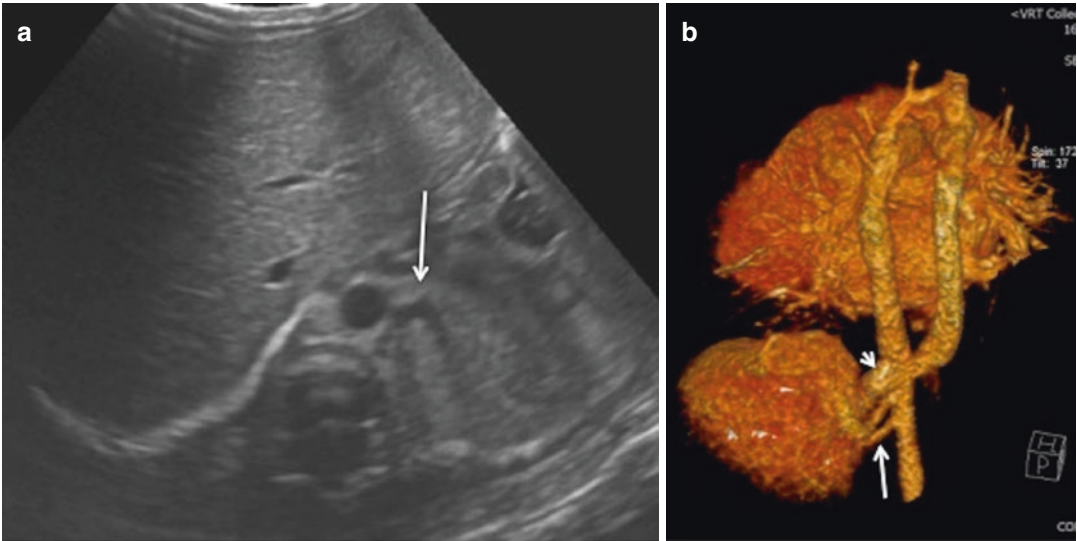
Sequestration (the lesion was detected antenatally). (a) Axial neonatal US scan on the upper abdomen showing hyperechogenic mass with a systemic feeding vessel (arrow) confirming the diagnosis of sequestration. (b) 3D reconstruction of the CE-CT scanner performed
